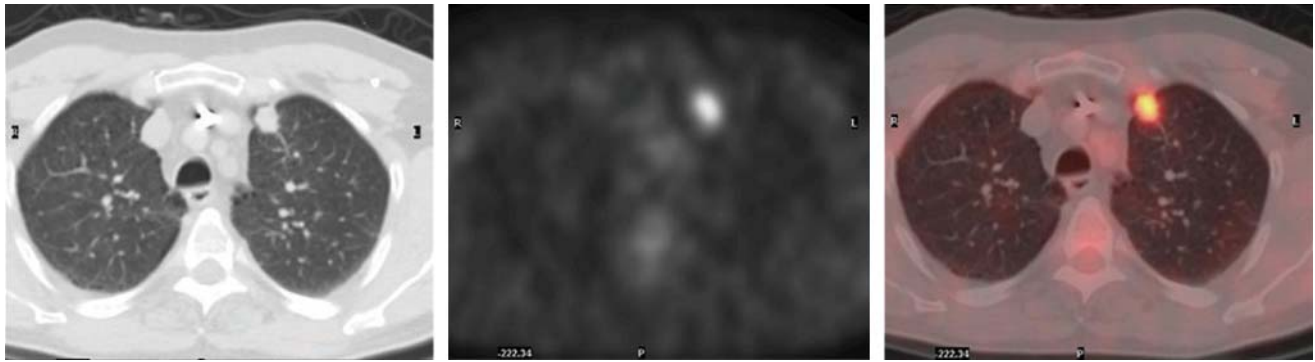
Solitary pulmonary nodule with spiculated borders in left upper lobe. No mediastinal adenopathy was present on additional images. Hypermetabolism is present within this nodule. Maximum SUV measures 6.7 g/mL. Findings are consistent with malignancy.
